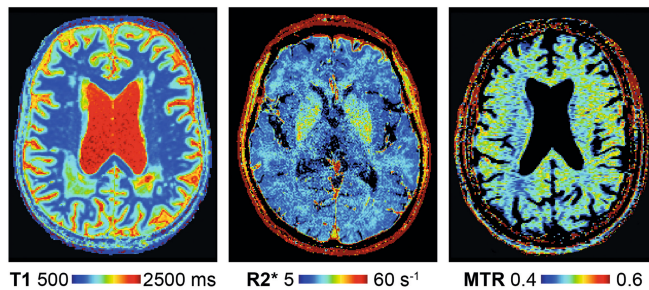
Quantitative MRI: (a) Analysis strategies for diffusion MRI can vary greatly in their complexity. (b) Relaxometry maps for T1 and R2* (1/T2*). Magnetization transfer ratio map as a proxy of myelin content.
